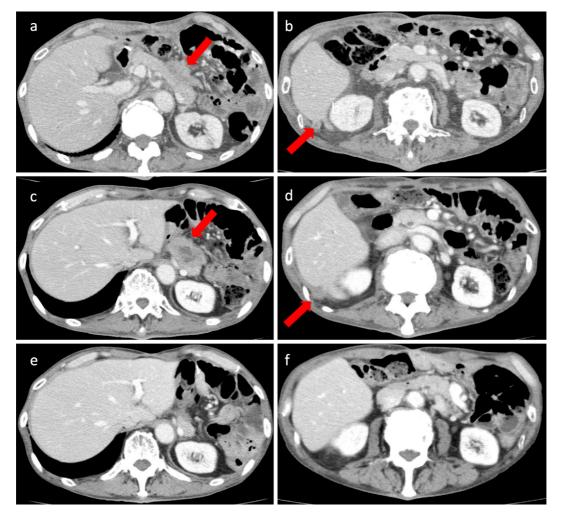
Contrast-enhanced CT images throughout the treatment course after palliative gastrectomy. CT images after palliative resection of the gastric lesion (a, b), after two cycles of paclitaxel with ramucirumab (c, d), and after three cycles of nivolumab (e, f). Arrows indicate remnant lesions on the anterior side of the pancreas (a, c) and the peritoneum (b, d). CT: computed tomography
